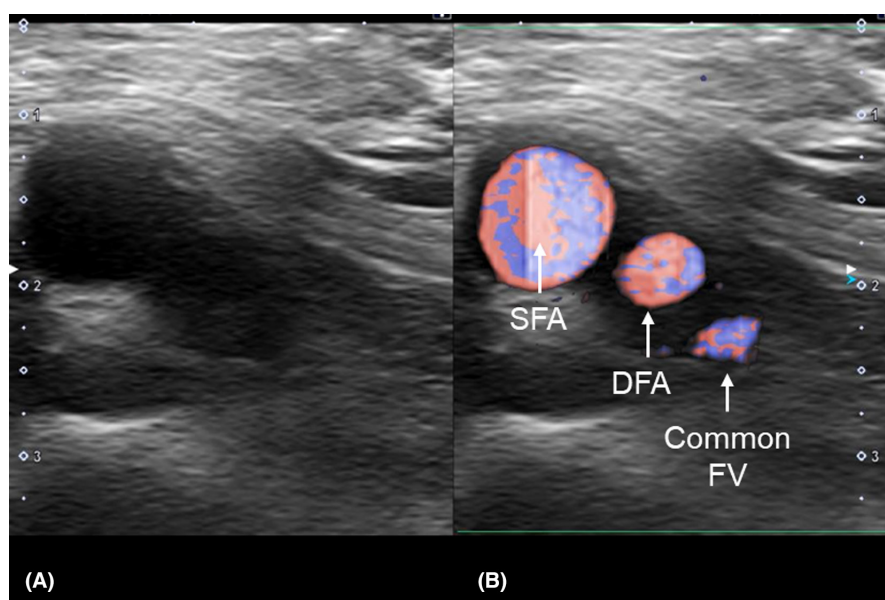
(A) Vascular ultrasound image of the right groin. (B) systolic phase with doppler. DFA, indicates deep femoral artery; FV, femoral vein; and SFA, superficial femoral artery.
